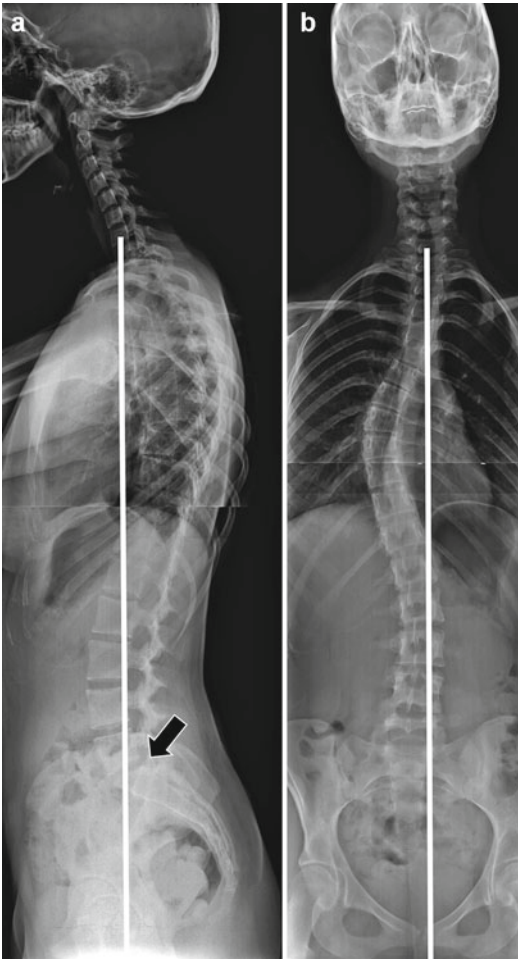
A 19-year-old female with idiopathic scoliosis. Large-format scoliosis radiographs in lateral (a) and frontal (b) projections. These large-format views allow for evaluation of the overall sagittal balance (a, white line) and coronal balance (b, white line). Appropriate sagittal balance is a plumb line that extends from the center of the C7 vertebral body inferiorly to intersect the dorsal margin of the S1 endplate (a, arrow). Coronal balance is measured with a plumb line that extends from the C7 spinous process inferiorly through the pubic symphysis/mid-sacrum. This patient demonstrates minimal anterior and left coronal imbalances of a degree that would not likely be considered clinically significant
